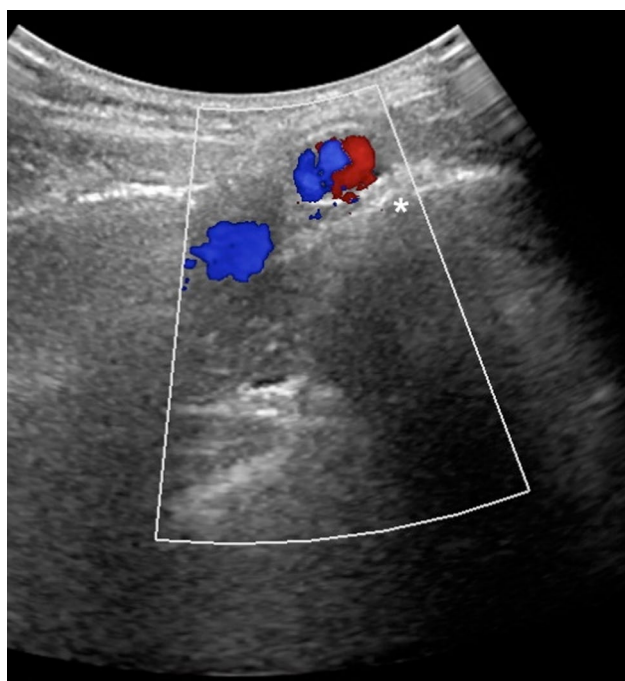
Color-coded duplex ultrasound in cross-sectional orientation at the apex of the hyperlordosis. The asterisk indicates the location of the anterior vertebral cortex. The dual flow signals (red for aortic bifurcation, blue for iliac vein confluents) can be appreciated. The large blue signal to the right belongs to the right renal vein
